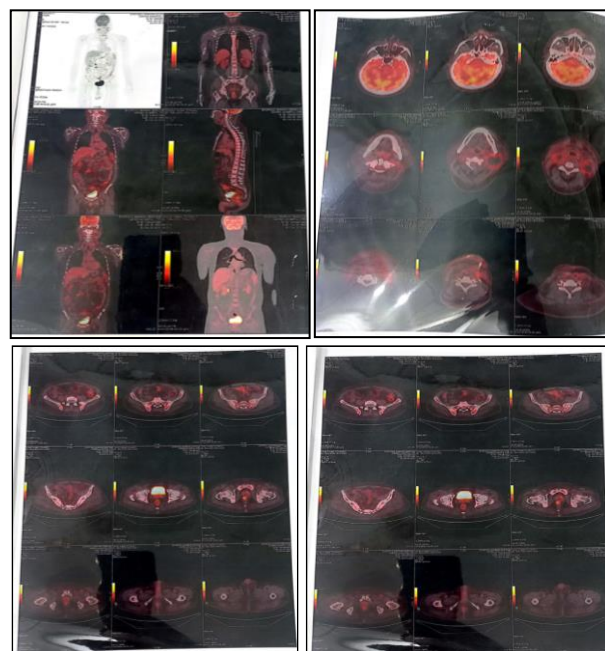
Whole body FDG PET/CT scan on 31st October 2021.
